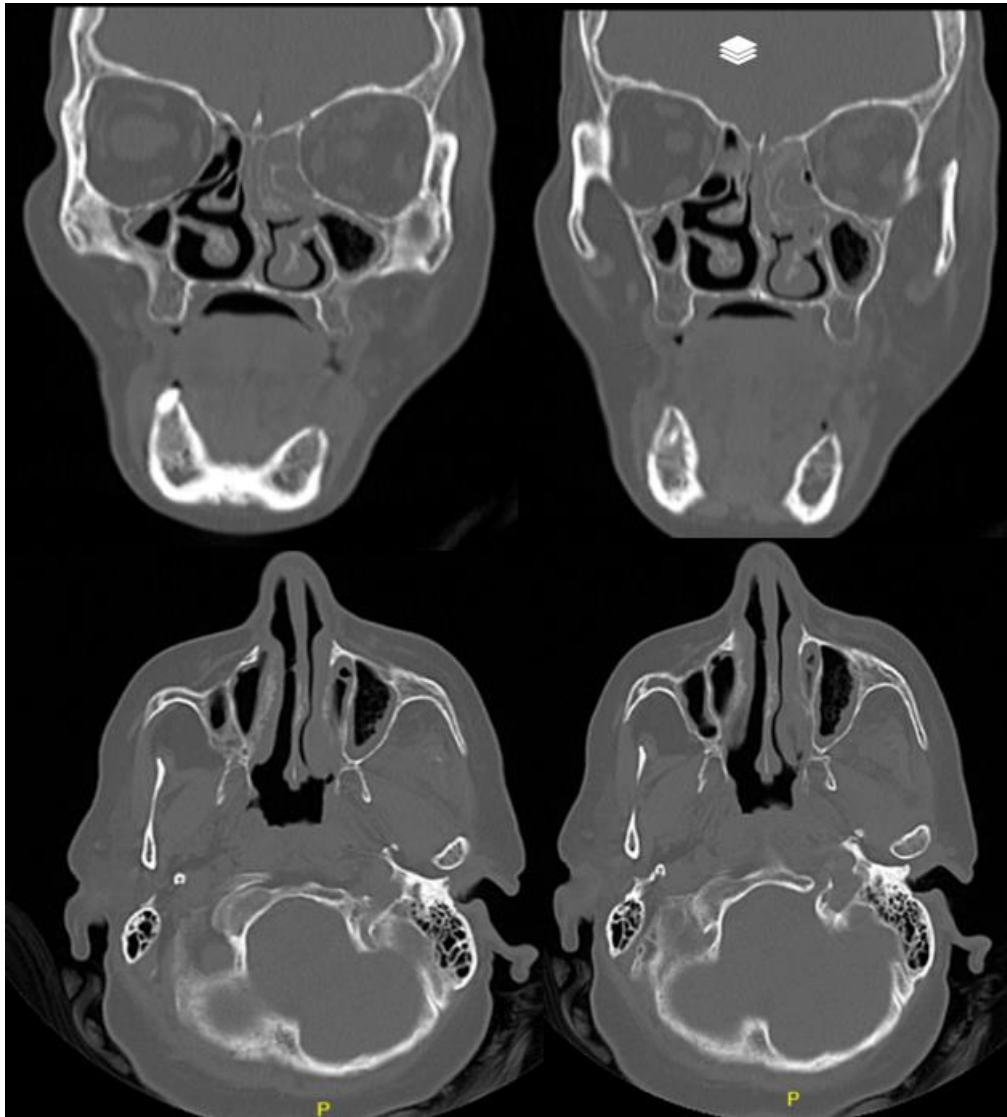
Maxillofacial CT showed clouding of the bilateral maxillary and ethmoid sinuses, with severe hypertrophy of the left nasal turbinates.
